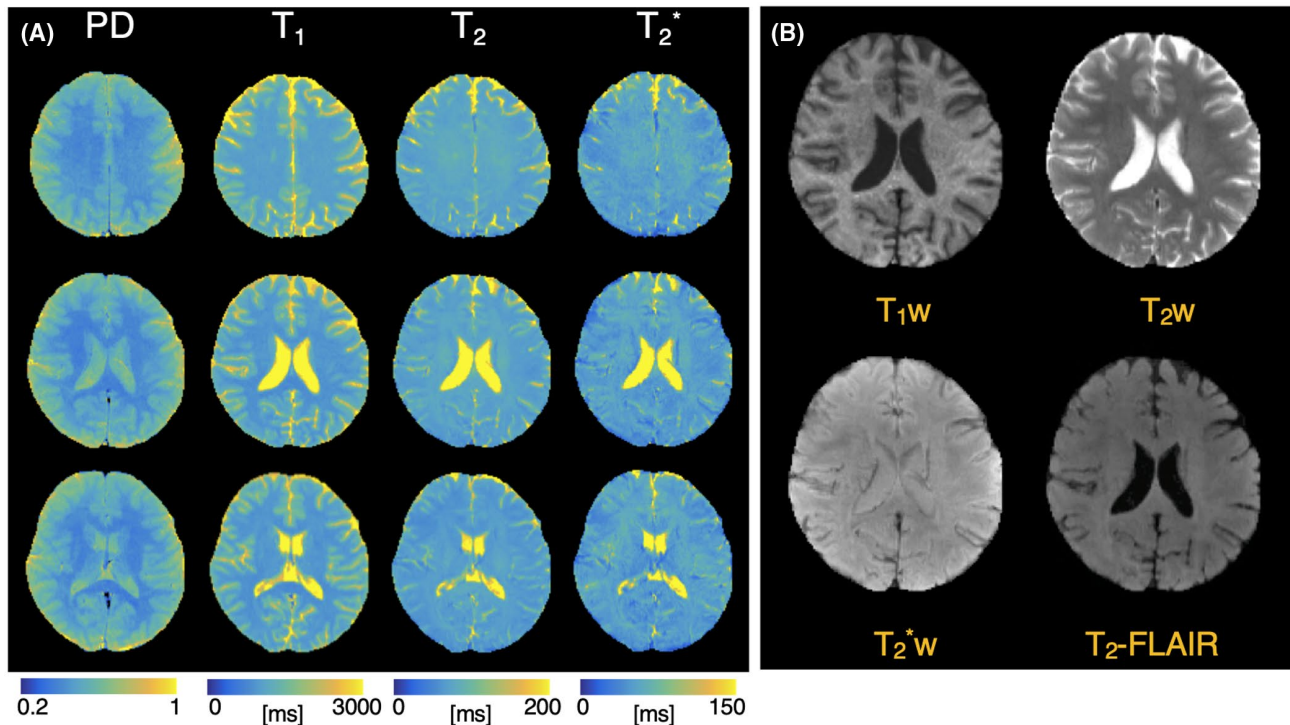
A, Quantitative parameter maps from protocol A, single-shot R = 4, acquired with dynamic slice-optimized MC shimming, in three representative slices. B, Synthetic weighted contrasts derived from the middle slice in A, with T₁w, T₂w, T₂^{*}w, and T₂-FLAIR images
